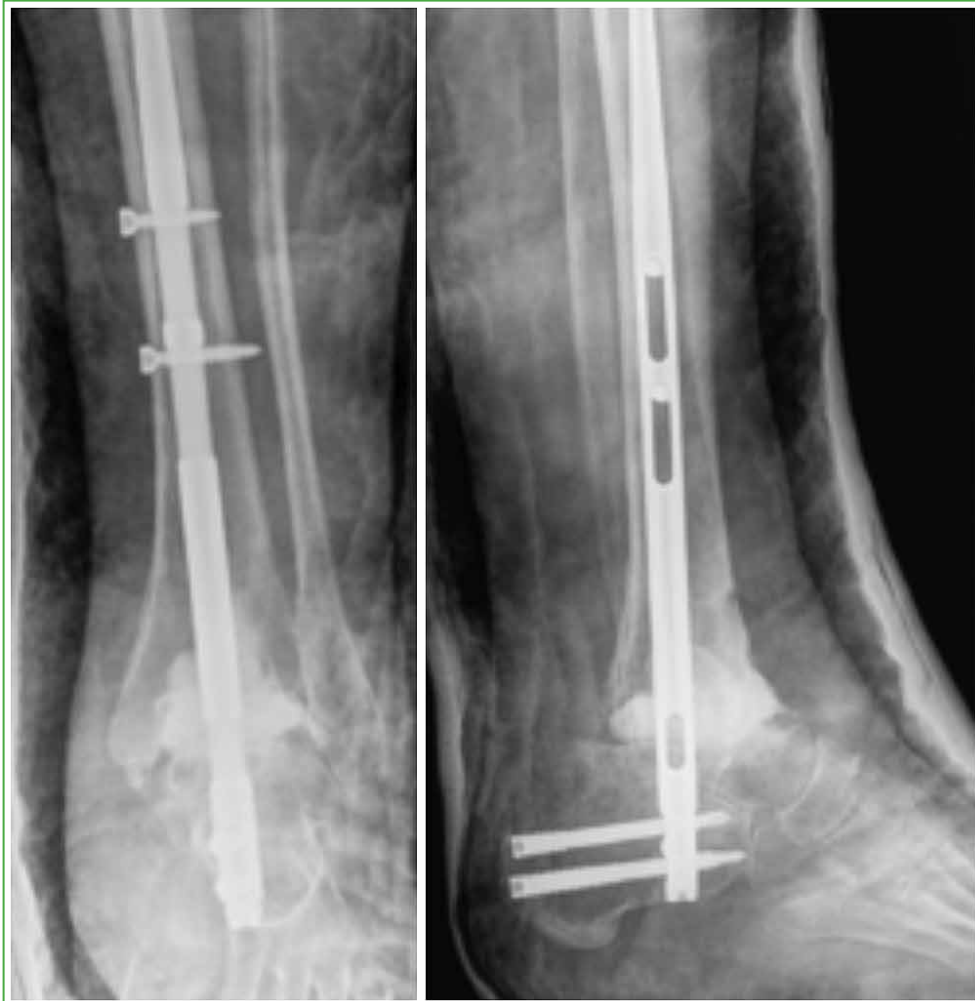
Anteroposterior and lateral ankle radiographs taken in the immediate postoperative period. Note the stabilization with a retrograde tibiototalcalcanal nail and the antibiotic-loaded cement that fills the bone defect.
